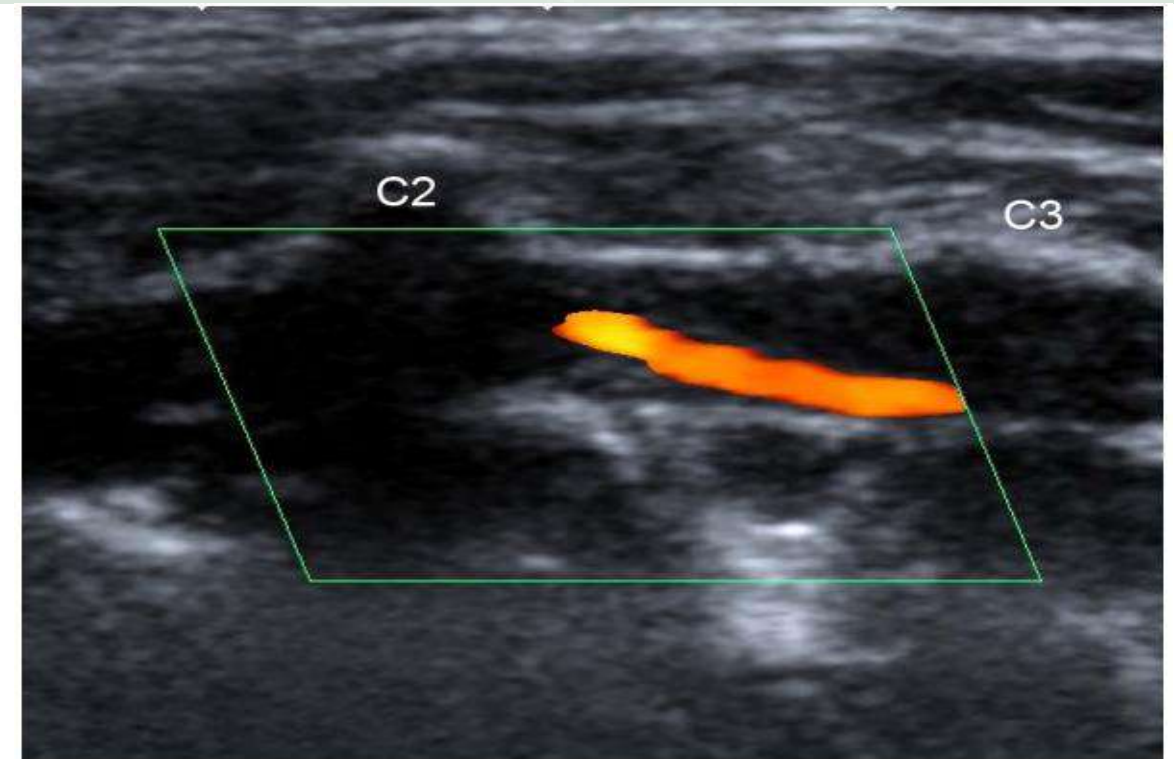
Color flow longitudinal duplex ultrasound highlights the severe luminal narrowing of left intervertebral VA due to intramural hematoma.
